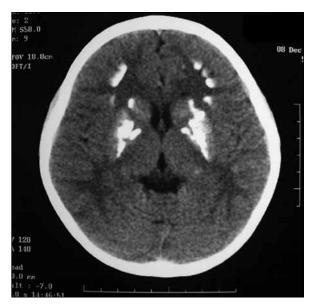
Computed tomographic scan of the brain showing calcification at the bilateral basal ganglia in a 6-year-old girl
